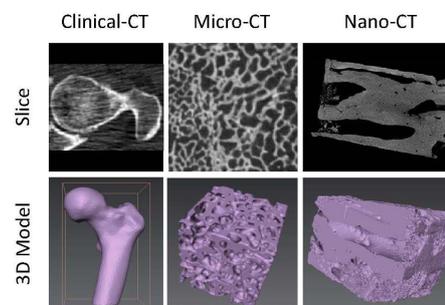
Micro-and nano-CT [20]
